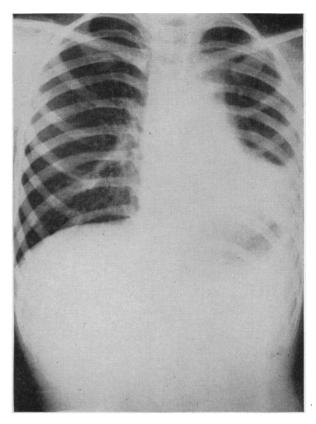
Roentgenogram of chest on January 14, 1958, showing left lower lobe atelectasis, elevation of diaphragm and mediastinal shift.
